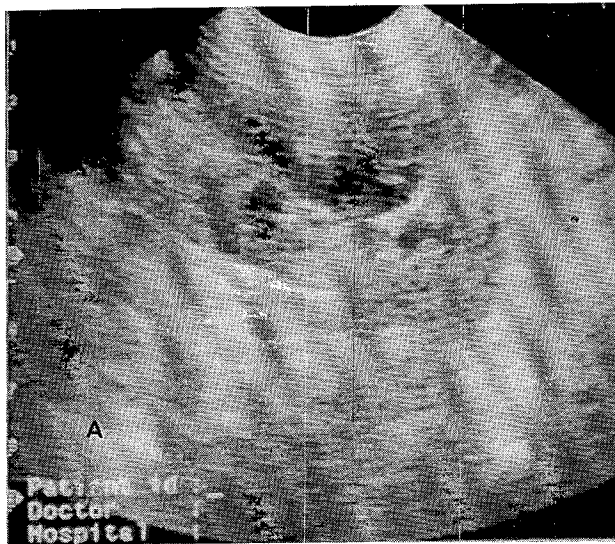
Ultrasonographic appearance of a heterogenous mass located in the cranial pole of the left kidney (A). Oblique ultrasound image of the same kidney with anechoic cavitory lesions and ureteral dilatation (B).
